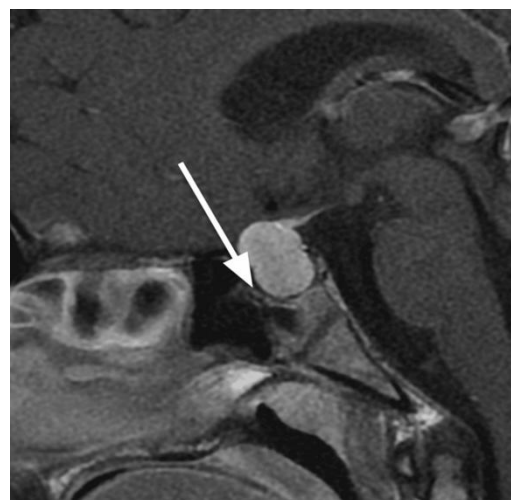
MRI Brain showing
